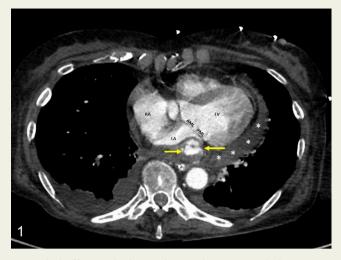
CT-scan revealing a pericardial effusion (*) together with a myocardial 3 cm mass protruding in the left atrium (yellow arrows) compatible with a perivalvular myocardial abscess with pseudoaneurysm. Abbreviations
